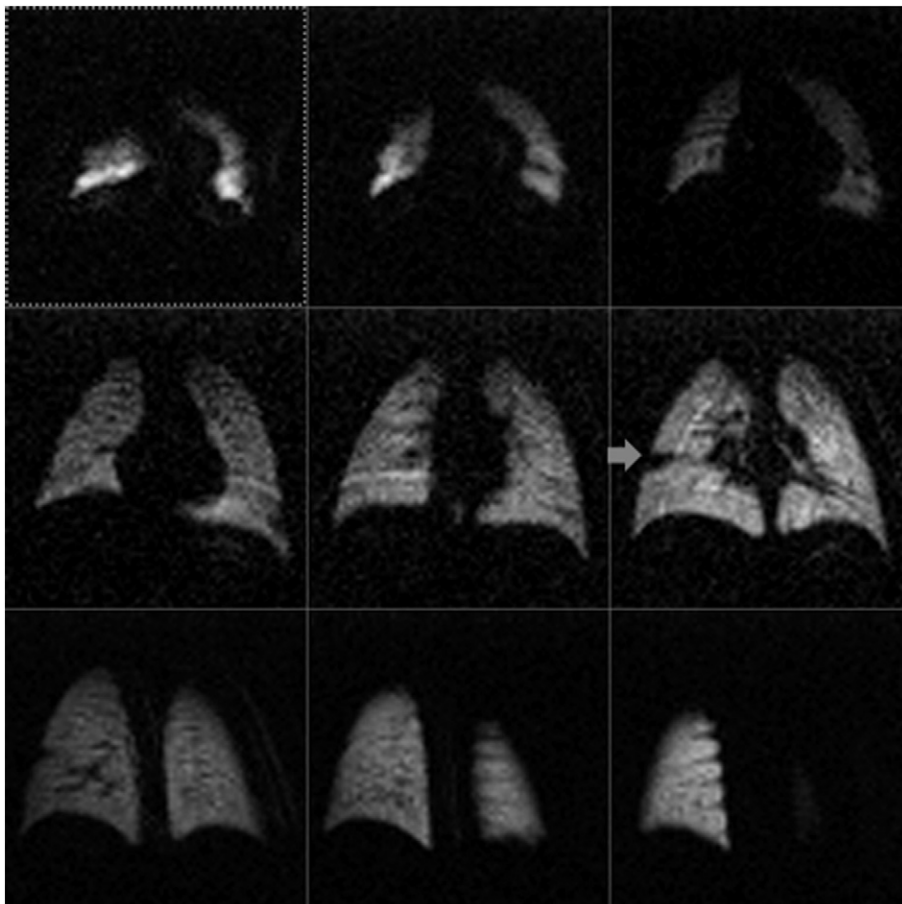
HHe coronal MR images of a 14-month-old non-sedated, unrestrained infant with CF. A small focal ventilation defect is seen in the right lung (arrow). Homogeneous ventilation is seen throughout the remainder of the lungs.
